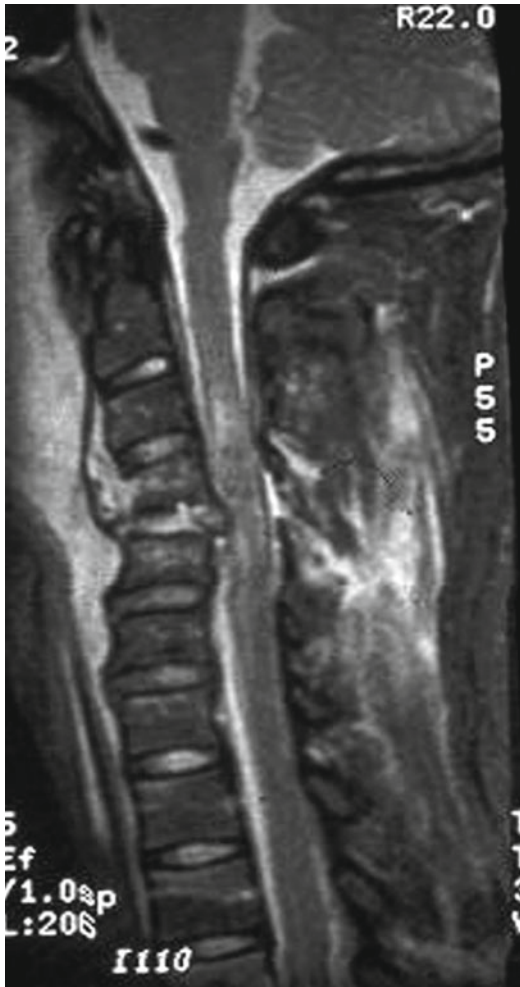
MRI of patient with C4 compression fracture and kyphosis. There is posterior ligamentous damage as well as spinal cord edema
